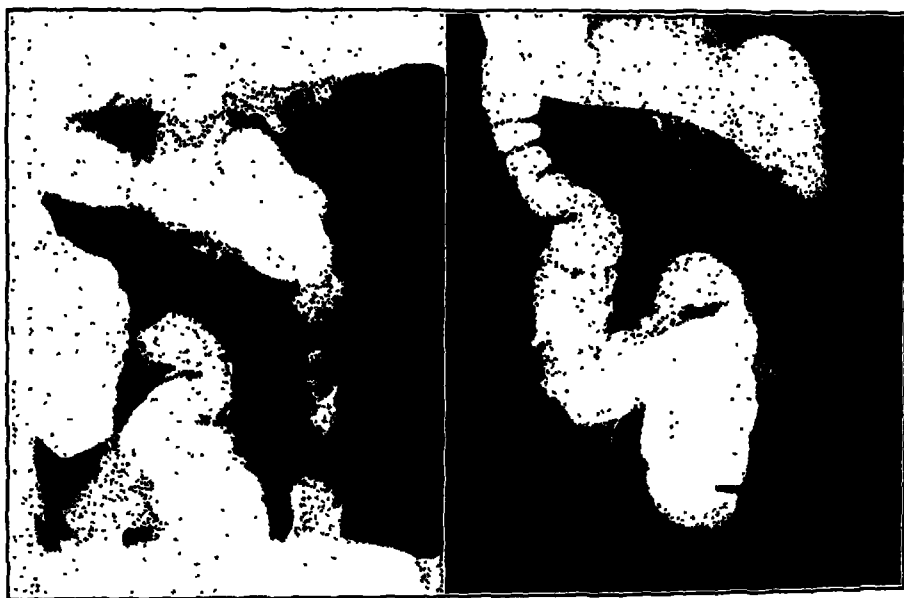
(case 4).—Roentgenograms, Aug. 31, 1927, made under fluoroscopic control following injection of barium enema, demonstrating the different phases of filling of the cecum and the ascending colon due to active spasm of these parts.
